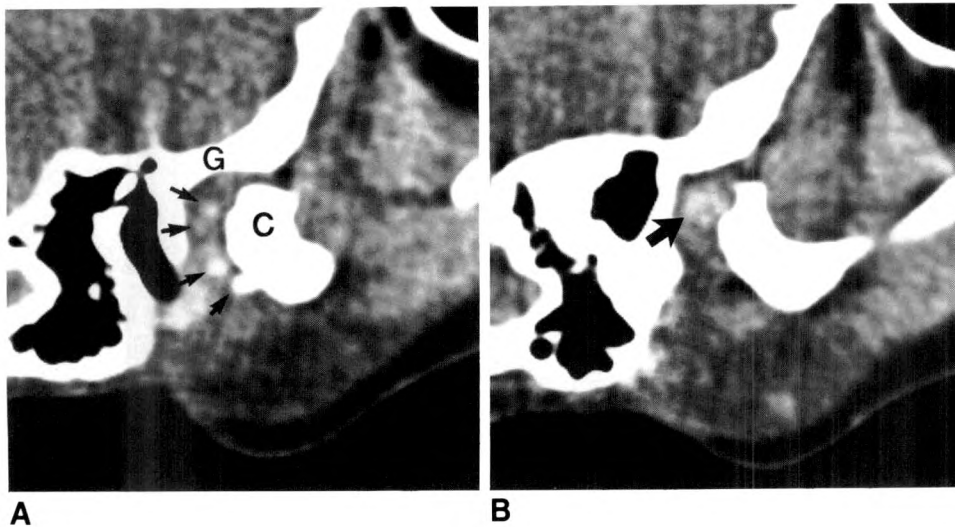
A, Direct sagittal CT scan in closed position shows several intra-articular, high-density, loose bodies (arrows) projecting into widened joint space. Condylar head (C) is displaced anteriorly to its normal point of articulation with glenoid fossa (G). Condylar head is mildly irregular and angulated. These findings strongly suggest synovial chondromatosis.
